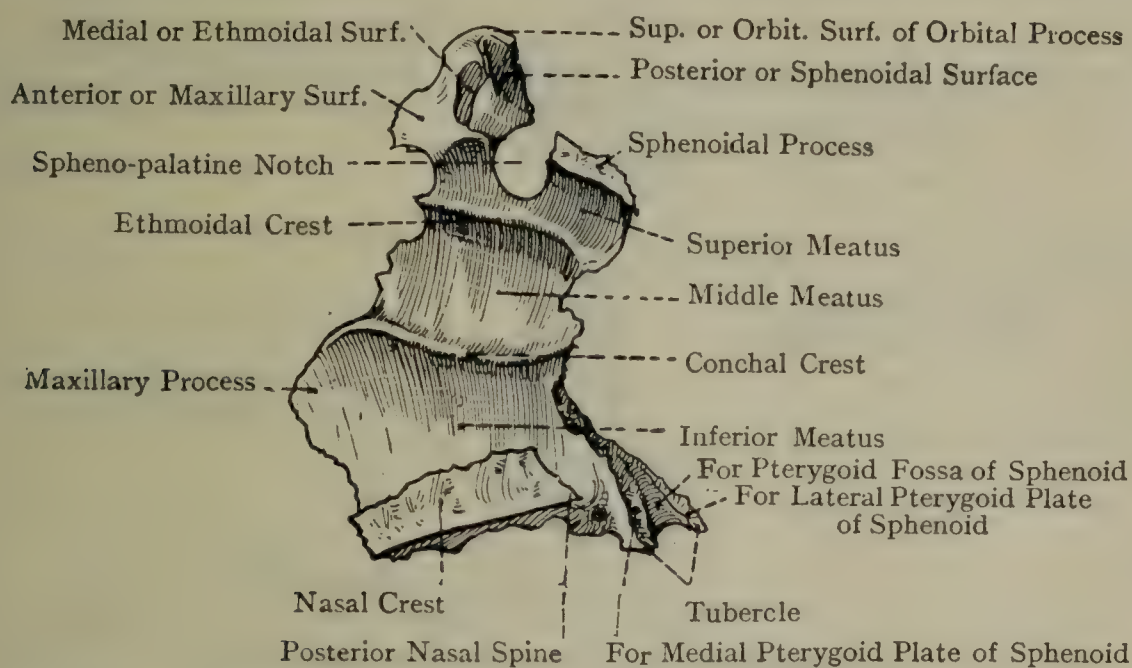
THE RIGHT PALATINE BONE (MEDIAL ASPECT).
